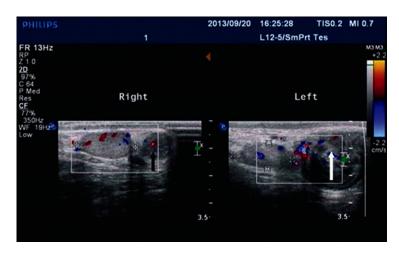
Sonography showed a tumor of 1.4 cm \times 1.1 cm in size (black arrow) beside the small hypoplastic right testis, and a tumor of 2.6 cm \times 2.2 cm in size (white arrow) beside the small hypoplastic left testis.
